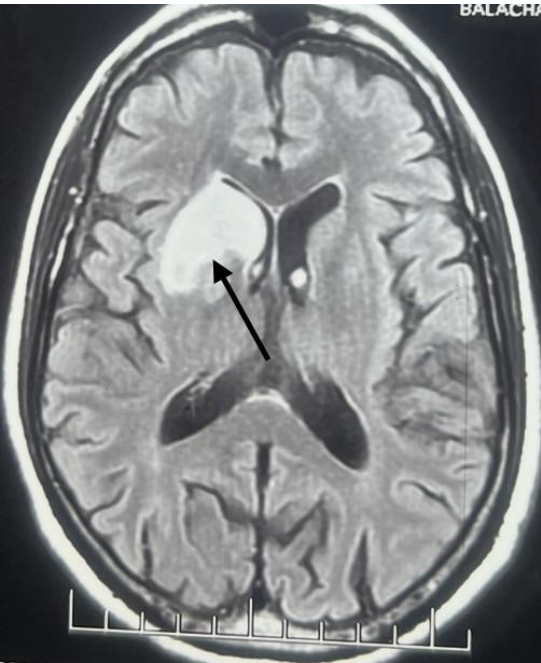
Axial FLAIR image showing hyperintensity of head of caudate nucleus and anterior lentiform nucleus and anterior limb of internal capsule.
